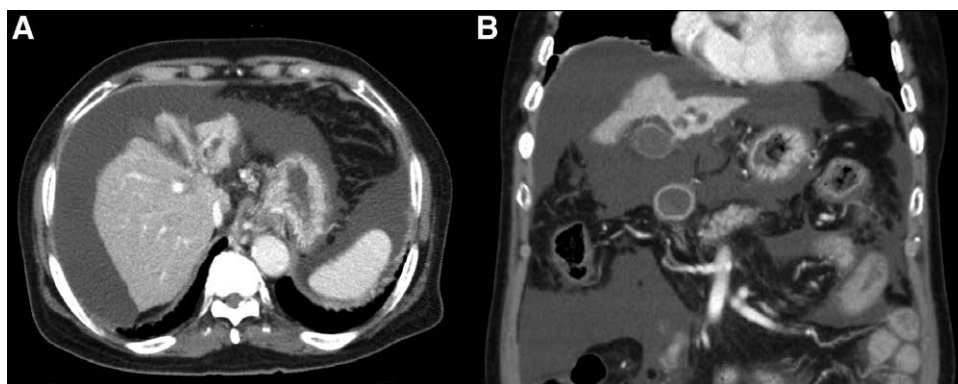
Peribiliary cysts in a 61-year-old male patient with a history of hepatitis B virus-related cirrhosis. Axial contrast-enhanced CT (A) and coronal contrast-enhanced CT (B) images show multiple cystic lesions with left-sided periportal distribution. CT = computed tomography.
